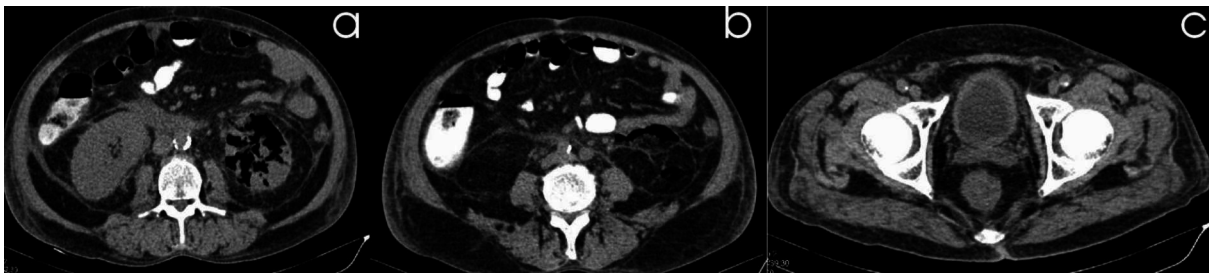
Abdomen computed tomography shows gas into the renal parenchyma (a) and into the perirenal space on the left (b). Gas can be seen into the left spermatic cord as well (c).
